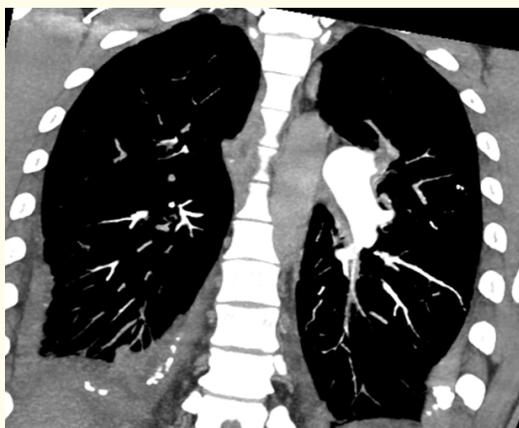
CT pulmonary angiography showing bilateral pleural effusion in addition to multiple hypodense filling defects bilaterally.
